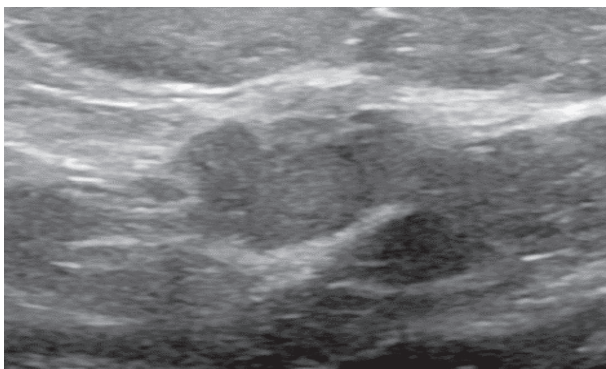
Left Breast Ultrasound Showed an Irregular Spiculated Outline Isoechoic Oval Shaped Solid Mass at 3 O'clock Position Close to the Areola (BI-RADS 5)
